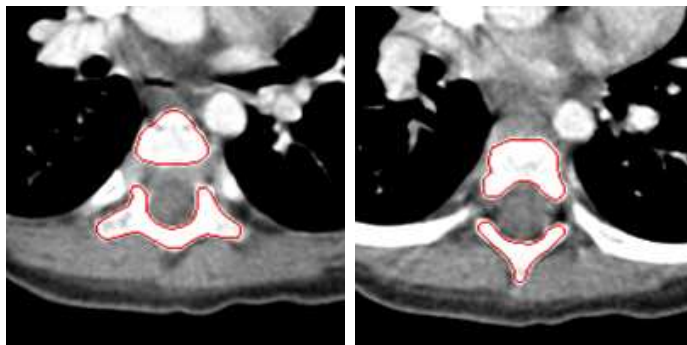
Intermediate results of spine segmentation. (a,b) Input CT images, (c,d) gradient maps, (e,f) results obtained by region growing, and (g,h) results after expansion.
